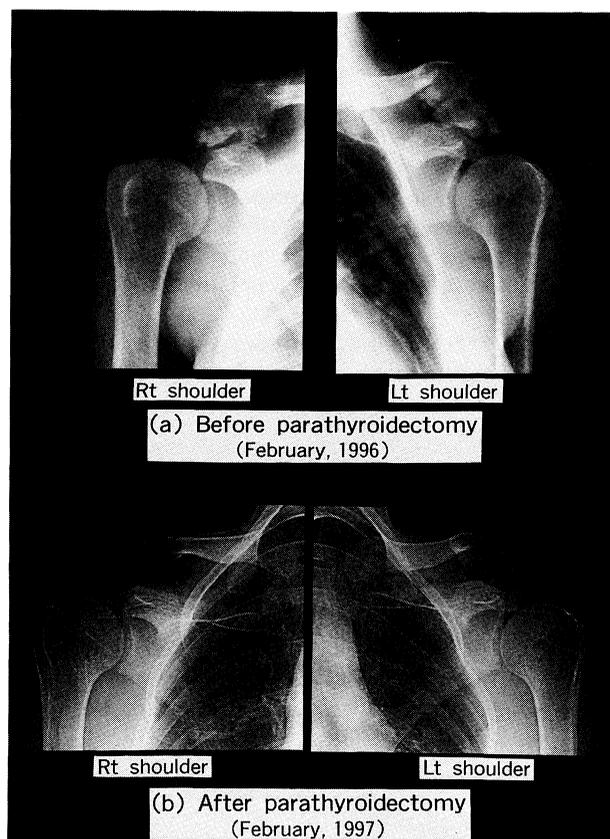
X-ray examination of the clavicles. (a) Severe destructive changes in the distal end of the clavicles before parathyroidectomy, and (b) dramatic recovery after parathyroidectomy.
